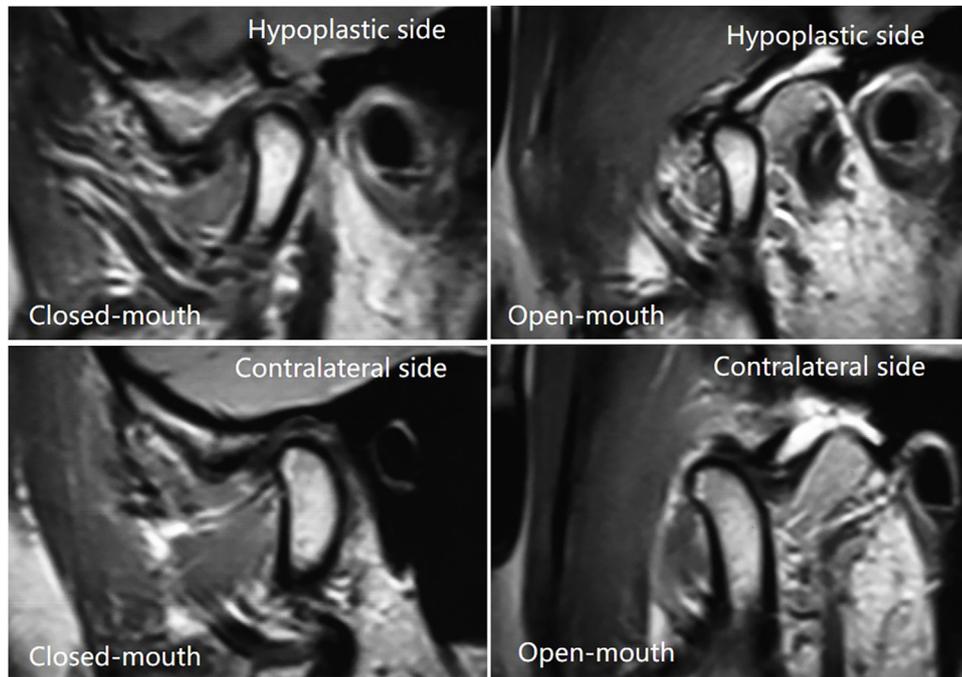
Bilateral temporomandibular joint magnetic resonance image of a patient. The disc length is shorter and disc displacement is greater on the hypoplastic side.
